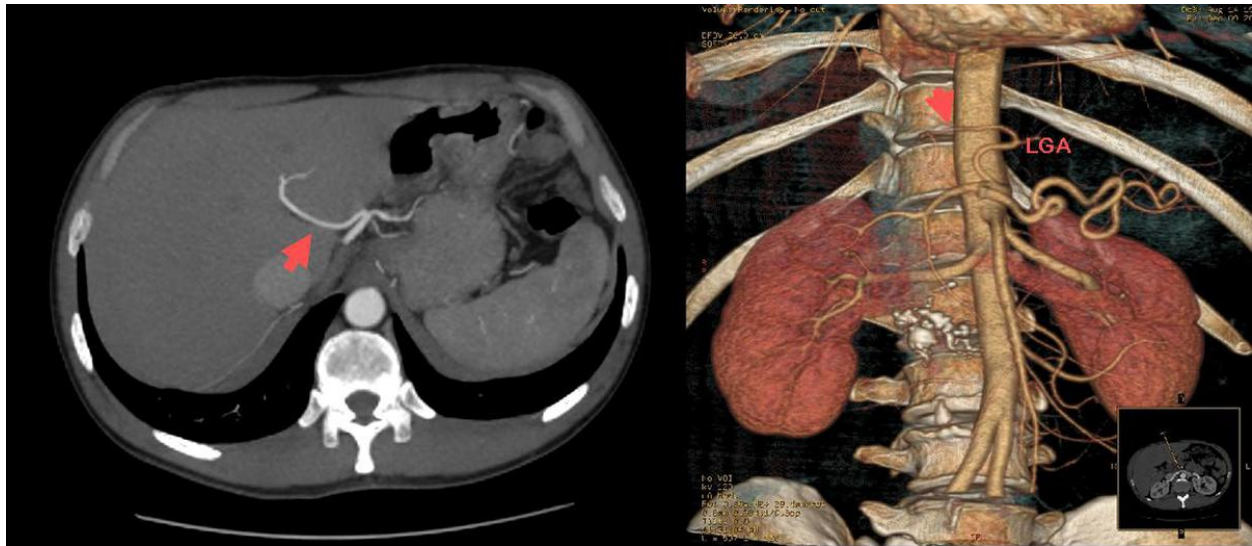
MIP and three-dimensional volume-rendered and maximum intensity projection CT angiography images showing a replaced left hepatic artery (arrows) arising from LGA and a normal right hepatic artery.
